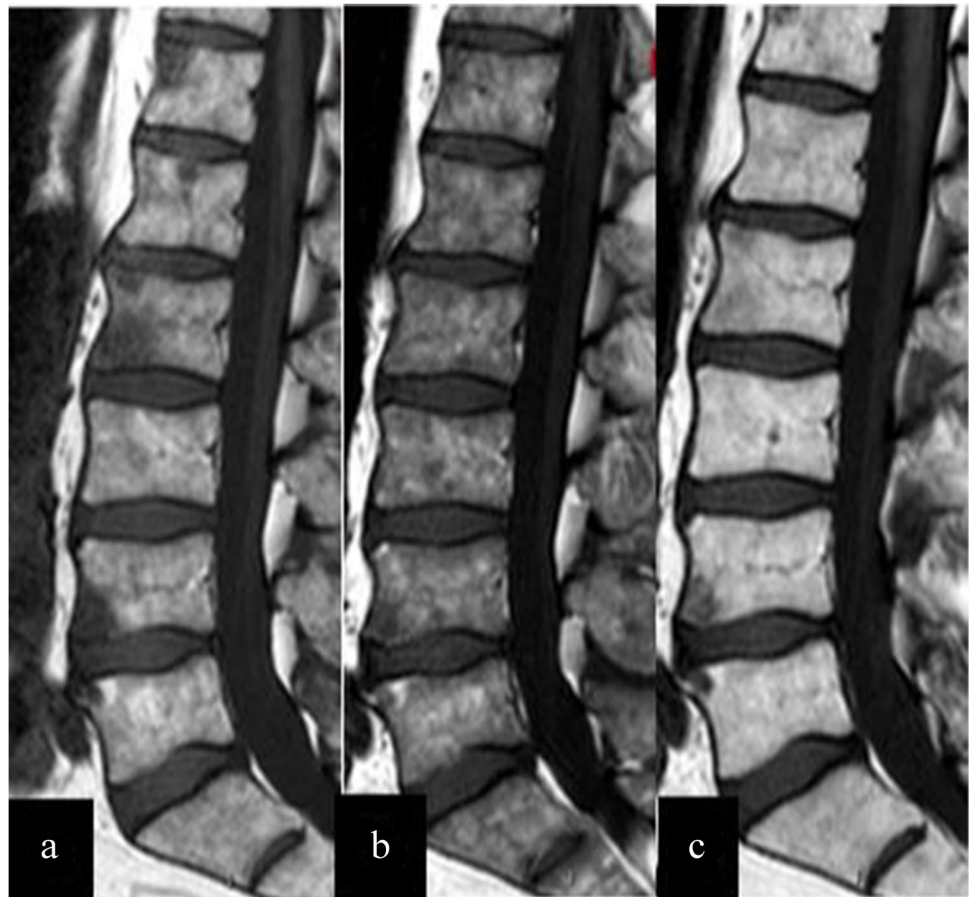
Serial sagittal T1 SE MRI images of the lumbar spine in a 66-year-old man with prostate cancer and bone metastases. a Before treatment, focal marrow lesions compatible with bone metastases are superimposed on a background of normal marrow. b During chemotherapy associated with granulocyte-colony stimulating factors, a variegated marrow pattern similar to that observed in patients with proliferative marrow disorders is observed. c Three months after treatment, the bone marrow appears normal and focal lesions (in a) are smaller
